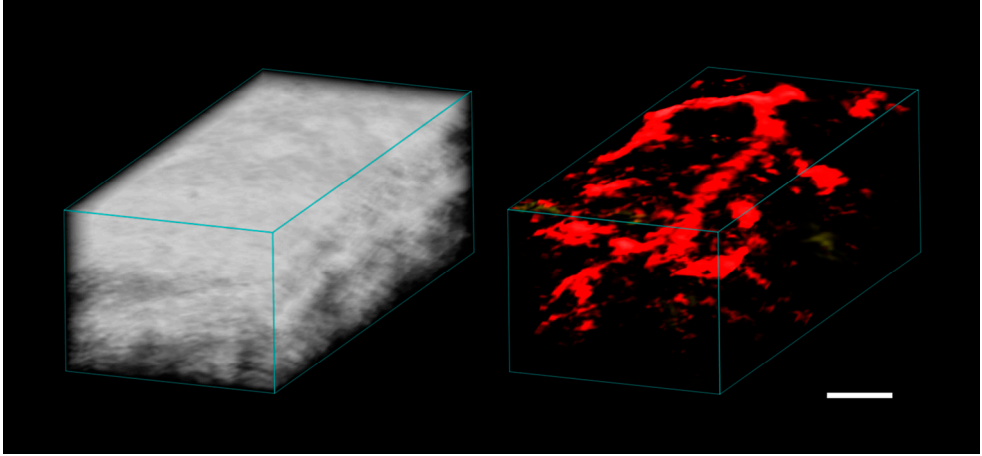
An example of 3D images obtained from a PAI examination of human skin *in vivo*. Left image shows the ultrasound image and the right shows the photoacoustic image, where the vascular network (red) is visible under the surface. Scale bar is 1 mm.
